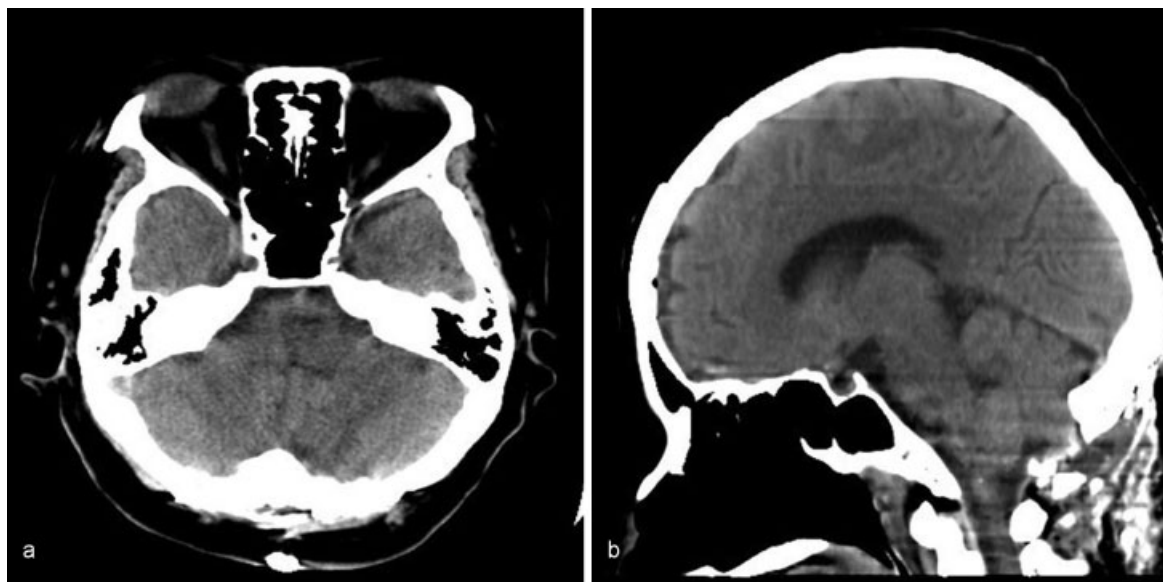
Postoperative computed tomography showing complete removal of the hematoma in the medulla oblongata. (a) Axial. (b) Sagittal.
